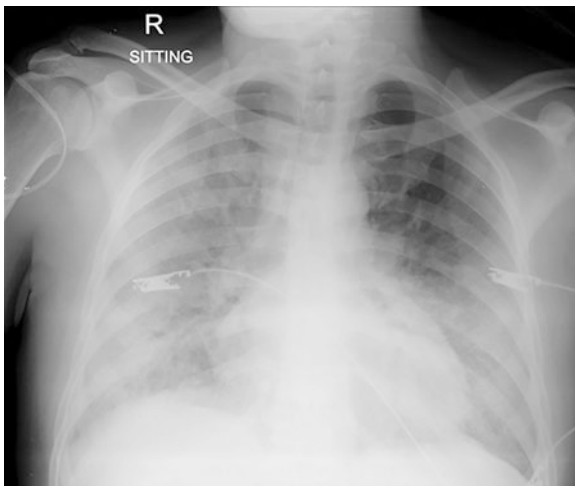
The above figure shows the consolidation including all but the left upper zone shown on this chest radiograph, indicating a severe deterioration. Sputum DFAT confirmed PCP, which was backed up by a β -D-glucan level of >500 pg/mL (normal 60). *Acinetobacter baumannii* was also found in blood cultures, for which colistin was started pending sensitivity. Legionella species were not found in the urine. On the eighth day, after admission to the ICU, the patient died of increasing respiratory failure. (Image reproduced with permission from [28])
